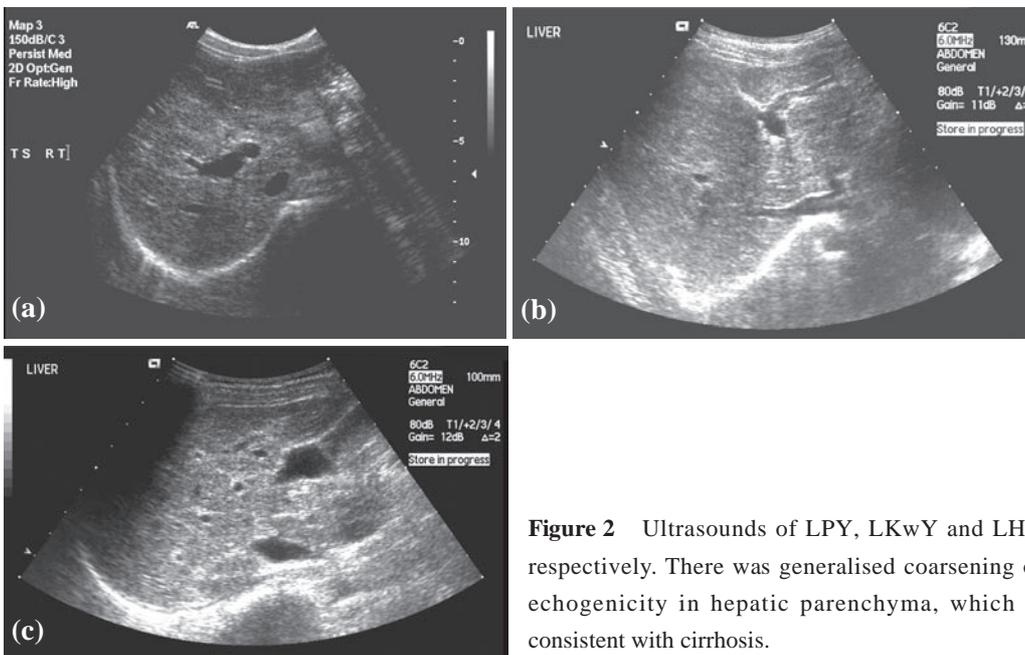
Ultrasounds of LPY, LKwY and LHY respectively. There was generalised coarsening of echogenicity in hepatic parenchyma, which is consistent with cirrhosis.
